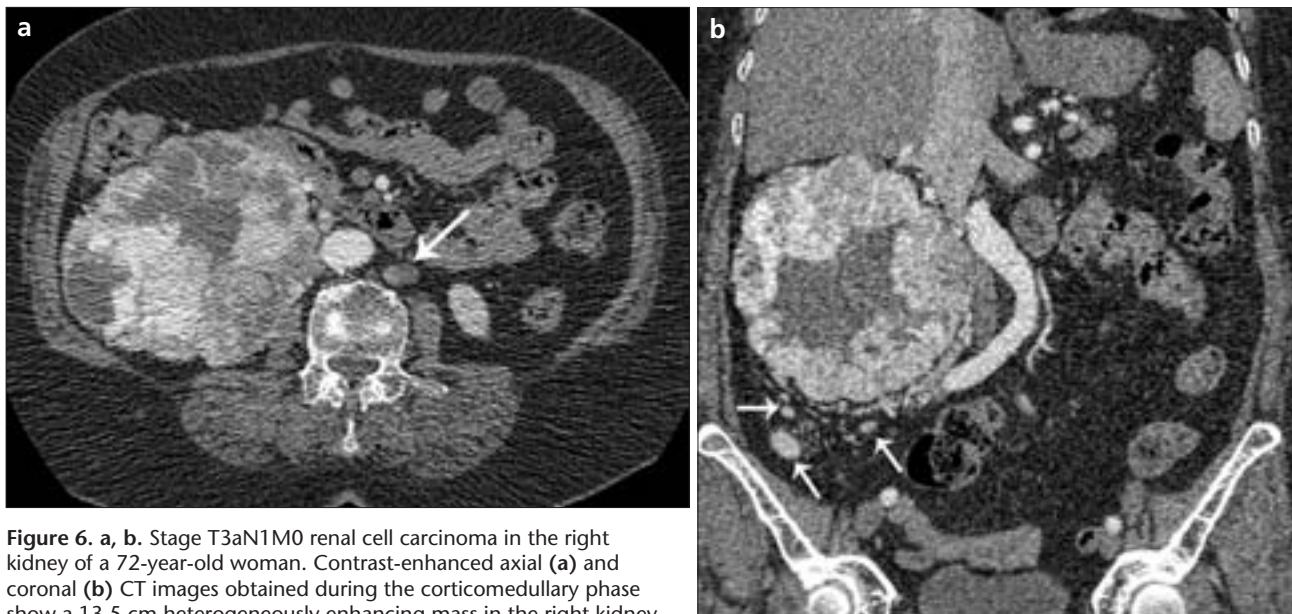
a, b. Stage T3aN1M0 renal cell carcinoma in the right kidney of a 72-year-old woman. Contrast-enhanced axial (a) and coronal (b) CT images obtained during the corticomedullary phase show a 13.5 cm heterogeneously enhancing mass in the right kidney. A lymph node with metastatic tumor is present in the paraaortic region (*long arrow, a*). Several enhancing tumor nodules and soft tissue stranding are seen in the right perinephric space (*short arrows, b*). The inferior vena cava was compressed by the tumor.
